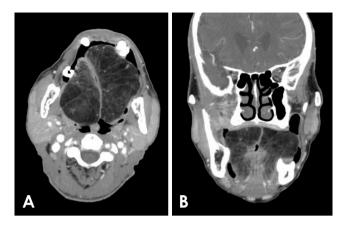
Enhanced computed tomography images show well-defined bilateral large masses of the tongue with homogeneous low density on axial (A) and coronal (B) scans.
